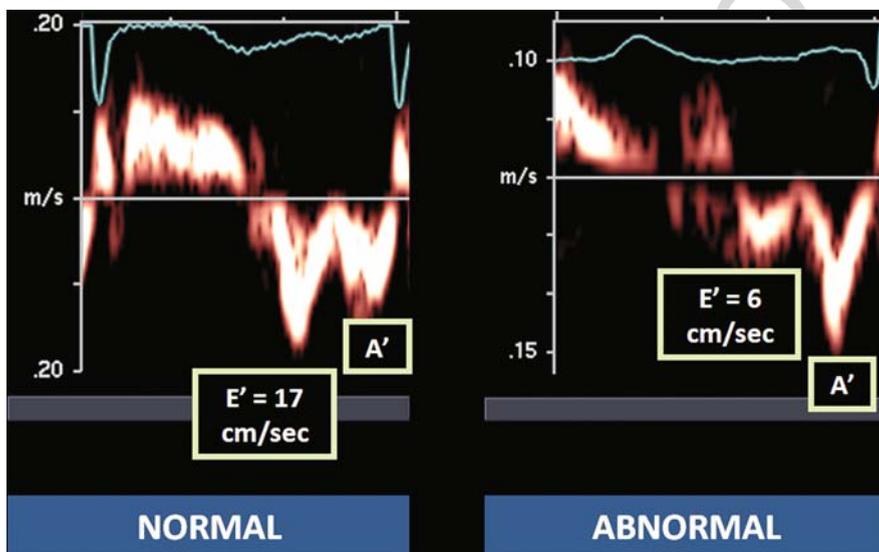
Normal and abnormal mitral annular tissue Doppler tracings. *Left panel* shows a normal pattern; *right panel* reveals diminished E' velocity consistent with abnormal left ventricular relaxation
